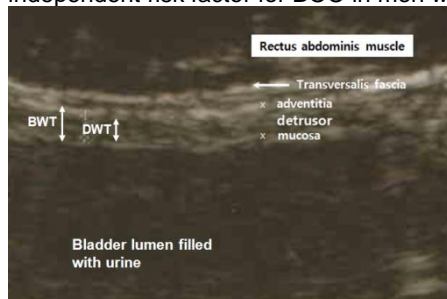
The structures of the anterior bladder wall were analyzed at enlarged digital ultrasound image (9x).
